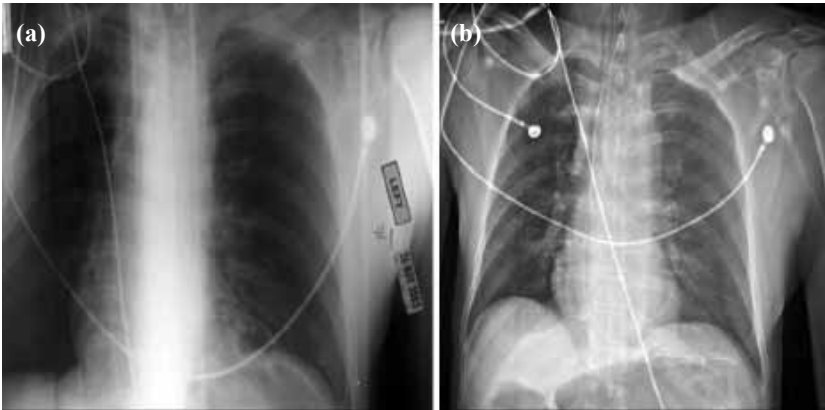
A 76 year-old male with multiple fractures following a motor vehicle accident. Traditional and Statscan® chest radiographs taken within 10 minutes of each other are presented for comparison. (a) A traditional chest x-ray shows multiple left-sided rib and clavicle fractures. (b) Statscan® imaging reveals the same fractures as well as a widened mediastinum.
